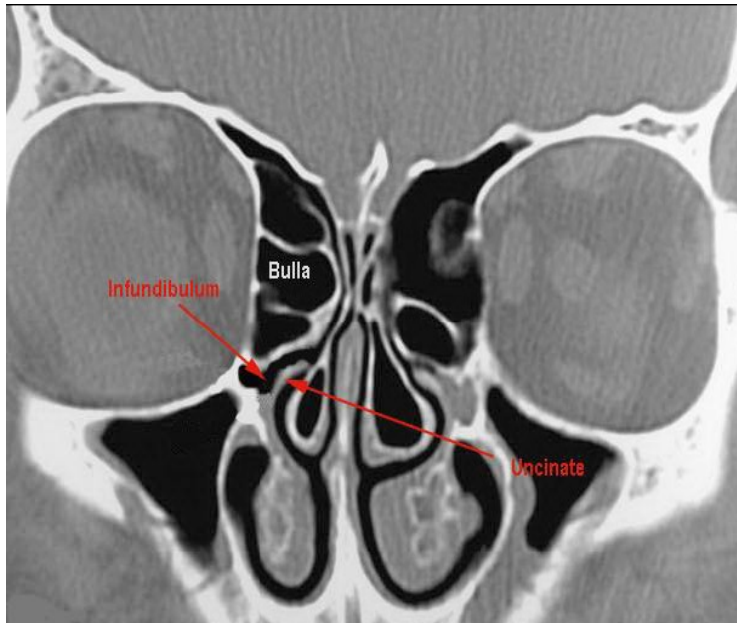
This coronal CT scan shows the uncinate process being attached to the middle turbinate. Note the presence of infundibulum between the bulla and the uncinate process. Frontal sinus is seen opening into the infundibulum. Note also the fairly deep olfactory fosse.
